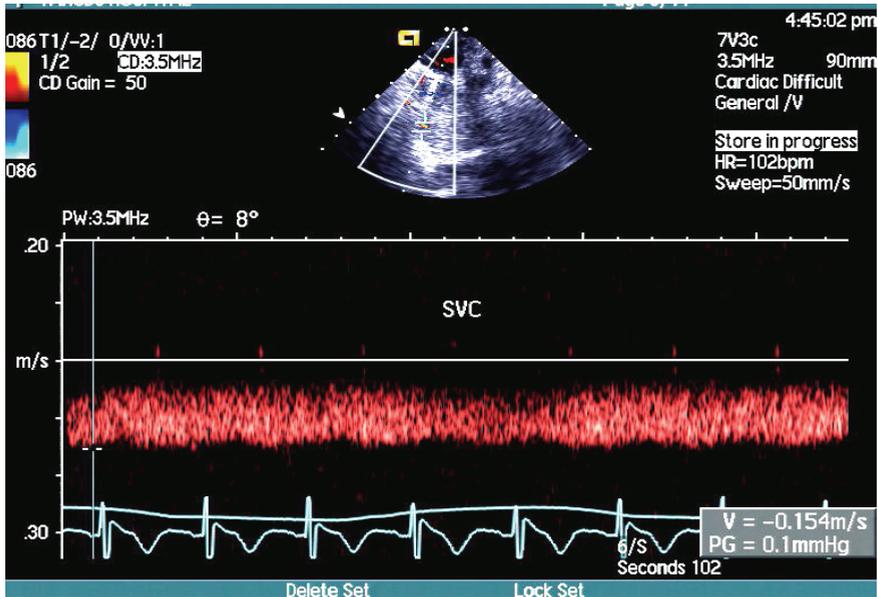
SVC Doppler flow spectra in severe SVCS. The S, D AR, and VR waves could not be identified
